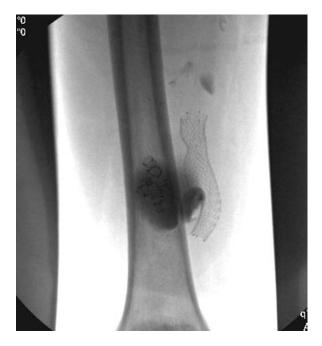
Radiography of left thigh (prone position) following stentassisted coil embolization of left superficial femoral vein aneurysm. Note delayed emptying of contrast from the aneurysm sac.
